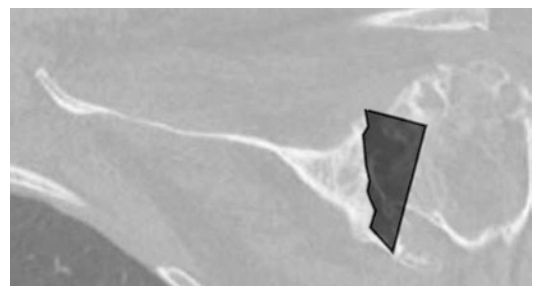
This coronal computed tomographic image demonstrates a substantial superior bone defect in the setting of a primary RTSA. The triangle demonstrates the likely defect
